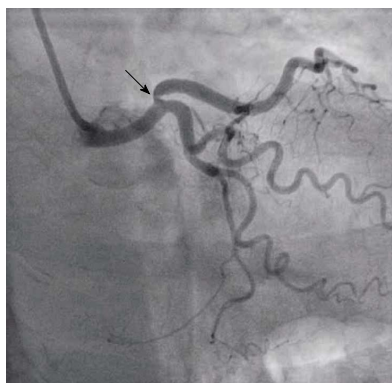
Artefactual angulated lesion on angiography. The coronary angiogram, shown here in the AP caudal view, appears to demonstrate a significant lesion in the proximal left anterior descending coronary artery (arrow). There was no significant impediment to flow on pressure wire study, with no significant lesion seen on intravascular ultrasound.
